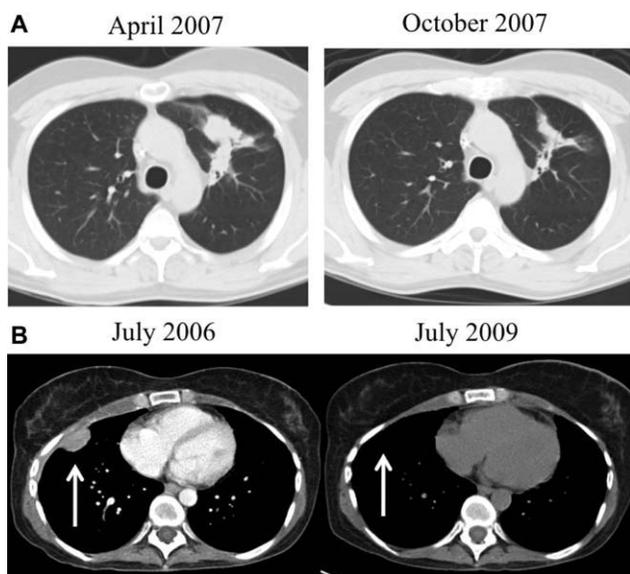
Computed tomography scans of two patients with relapsed Hodgkin lymphoma who responded to single-agent everolimus. (A) Patient with left lung parenchymal relapsed HL who obtained a partial response to everolimus. He had a 10-month time to progression. (B) Patient with right chest wall involvement has experienced a complete response to everolimus. She has been on study for 36+ months.
